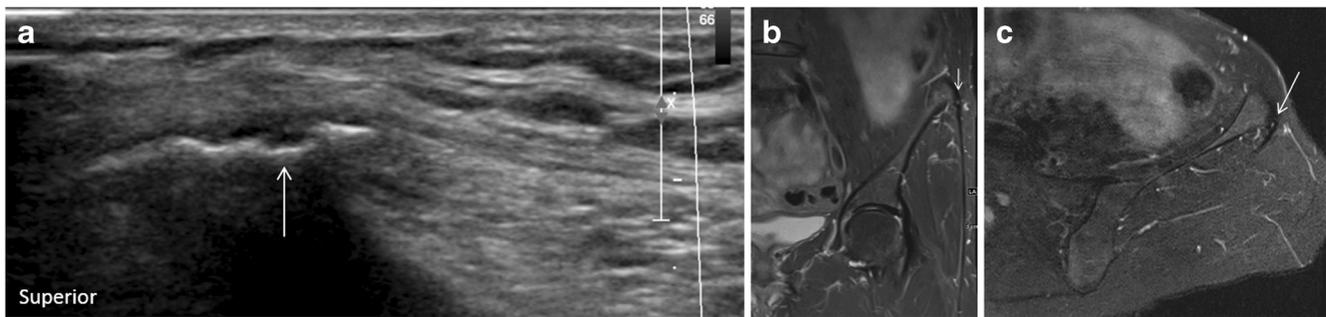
A 59-year-old female with left hip pain. a Longitudinal ultrasound demonstrates small partial thickness tears within the left gluteal contribution to the FLAIC. Linear mineralization at the iliac crest is compatible
